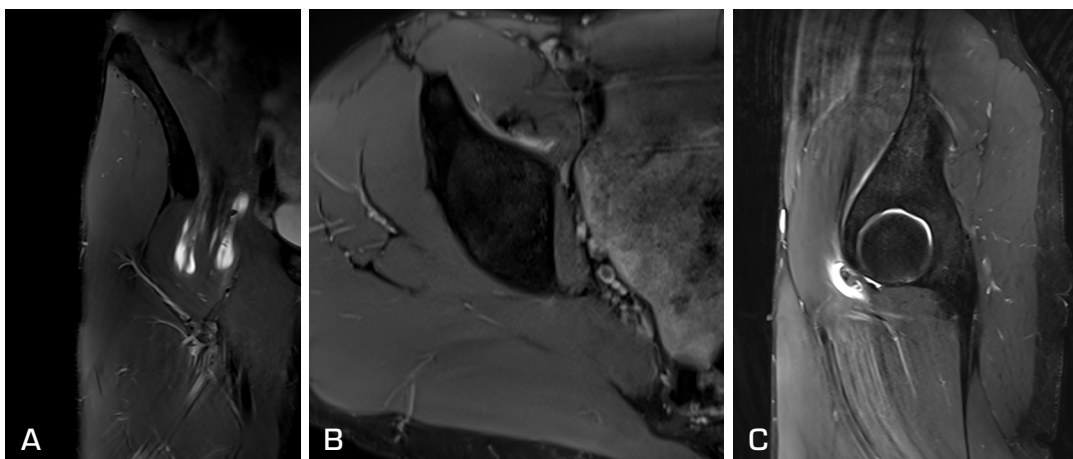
Control MRI 15 days post-grade 2b iliopsoas muscle injury. T2-weighted sequence. (A) Coronal plane. (B) Axial plane. (C) Sagittal plane.
